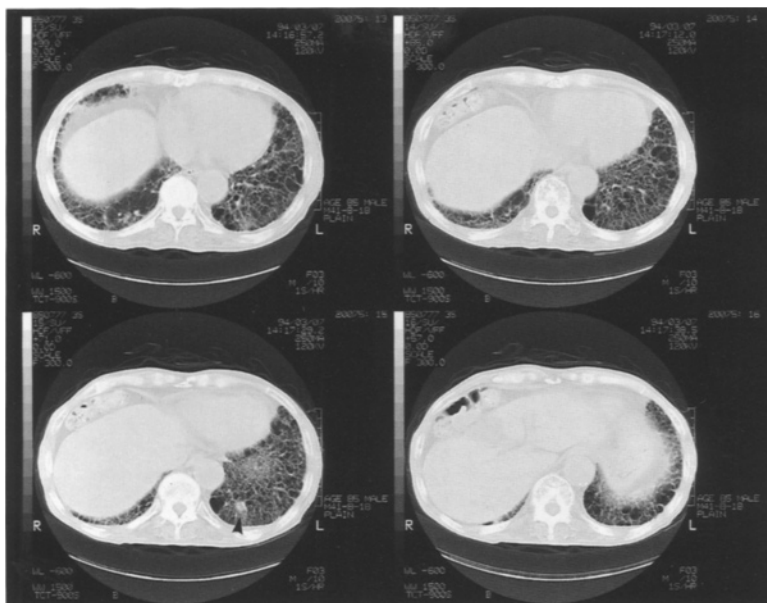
CT images of the lower lung zones show extensive areas of honeycombing and an irregular shaped nodule in the left lower lung posteriorly (*arrowhead*), suggesting a possible lung cancer
